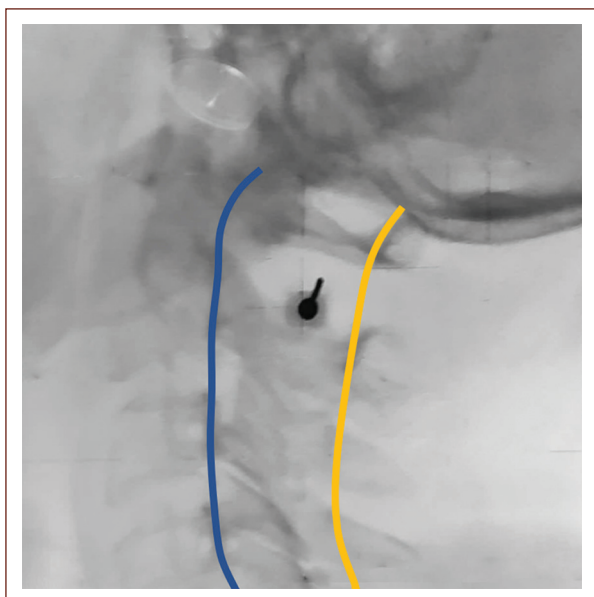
X-ray of the cervical spine showing the spinolaminar line in yellow and the posterior vertebral line in blue. Cervical puncture was performed near to the spinolaminar line, the needle is shown between them.
